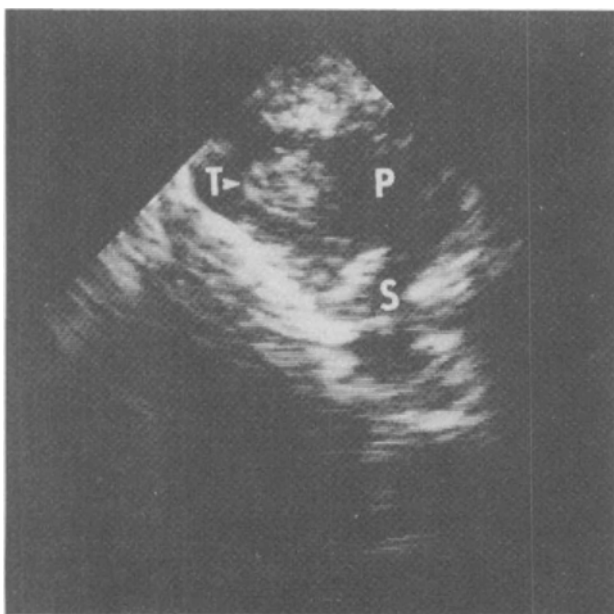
Transoesophageal echocardiographic image showing large thrombus (T) in proximal right pulmonary artery (P), which could not be seen on surface echocardiography. S, superior vena cava. (Reproduced with permission from Fyfe *et al.* The utility of transoesophageal echocardiography during and after the Fontan operations in small children. *Am Ht J* 1991; 122: 1403–15.)
